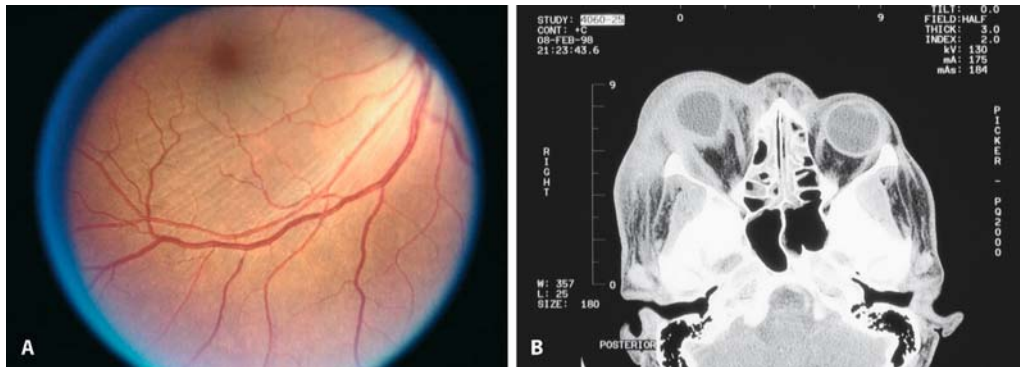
A, B. Inflammatory pseudotumor (orbital mass section) in a young female patient. A Colour photo. B CT scan
